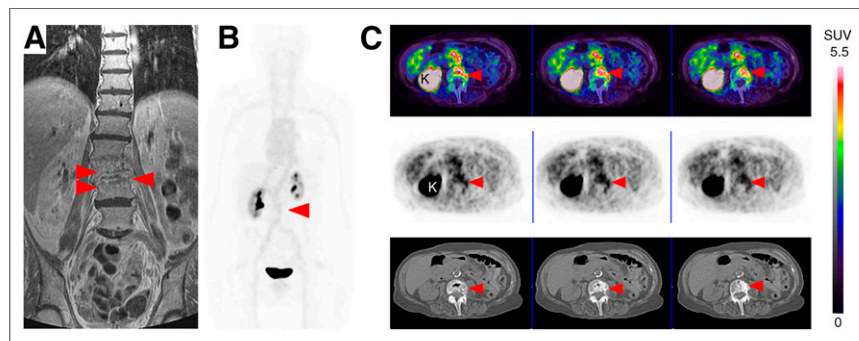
Representative MR and ^{68}Ga -NOTA-UBI PET/CT images in patient with suspected spinal infection (spondylodiskitis). (A–C) Coronal T1-weighted MR image (fat suppression) (A), whole-body maximum-intensity-projection PET image (B), and sequential transaxial fused PET/CT (top), PET (middle), and CT (bottom) images (C) showing focally increased uptake (arrowheads) in intervertebral region of L3–L4 corresponding to abnormal findings on MRI. K = kidney.
